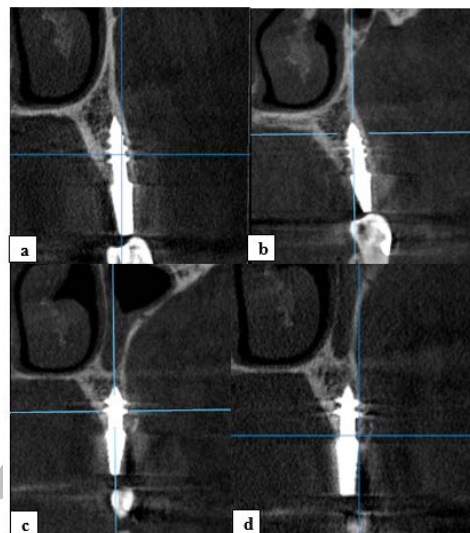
CBCT image of implant taken (a,b) photographs of postoperative CBCT showing implants in the first and second maxillary premolar sites immediately postoperative (c,d) photographs of postoperative CBCT showing implants in the first and second maxillary premolars sites after 3 months.
